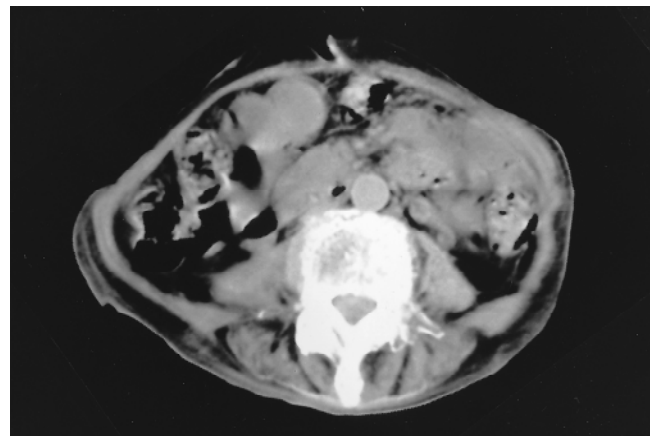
CT scan of the abdomen showing intact psoas muscles 52 days after admission
